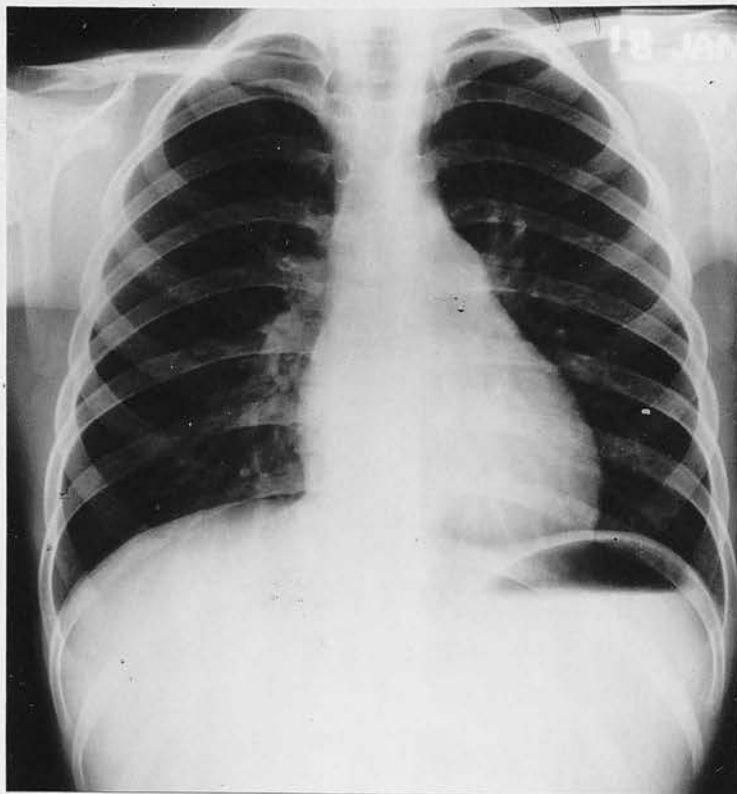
Radiograph of Case 8. True reduction in cardiac size following ligation of Patent Ductus Arteriosus at 18yrs.
